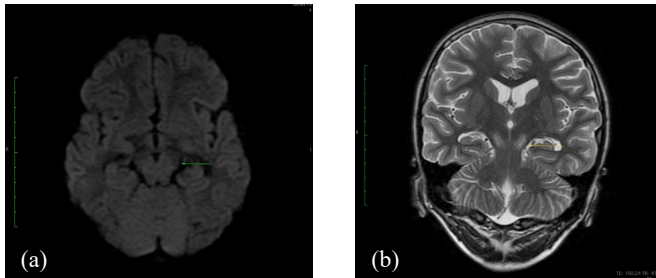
AX DWI showing hypointense signals in the substantia nigra representing a lack of restricted diffusion (b) COR T2 showing hyperintense signals in the substantia nigra.
